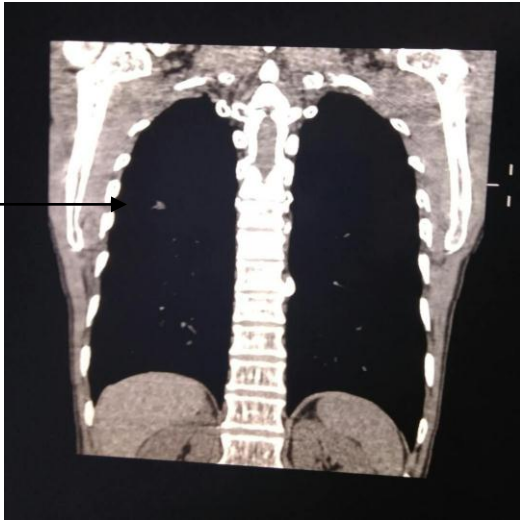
Coronal view of chest CT showing ill-defined nodule with ground glass appearance in the lower part of upper lobe of right lung.
